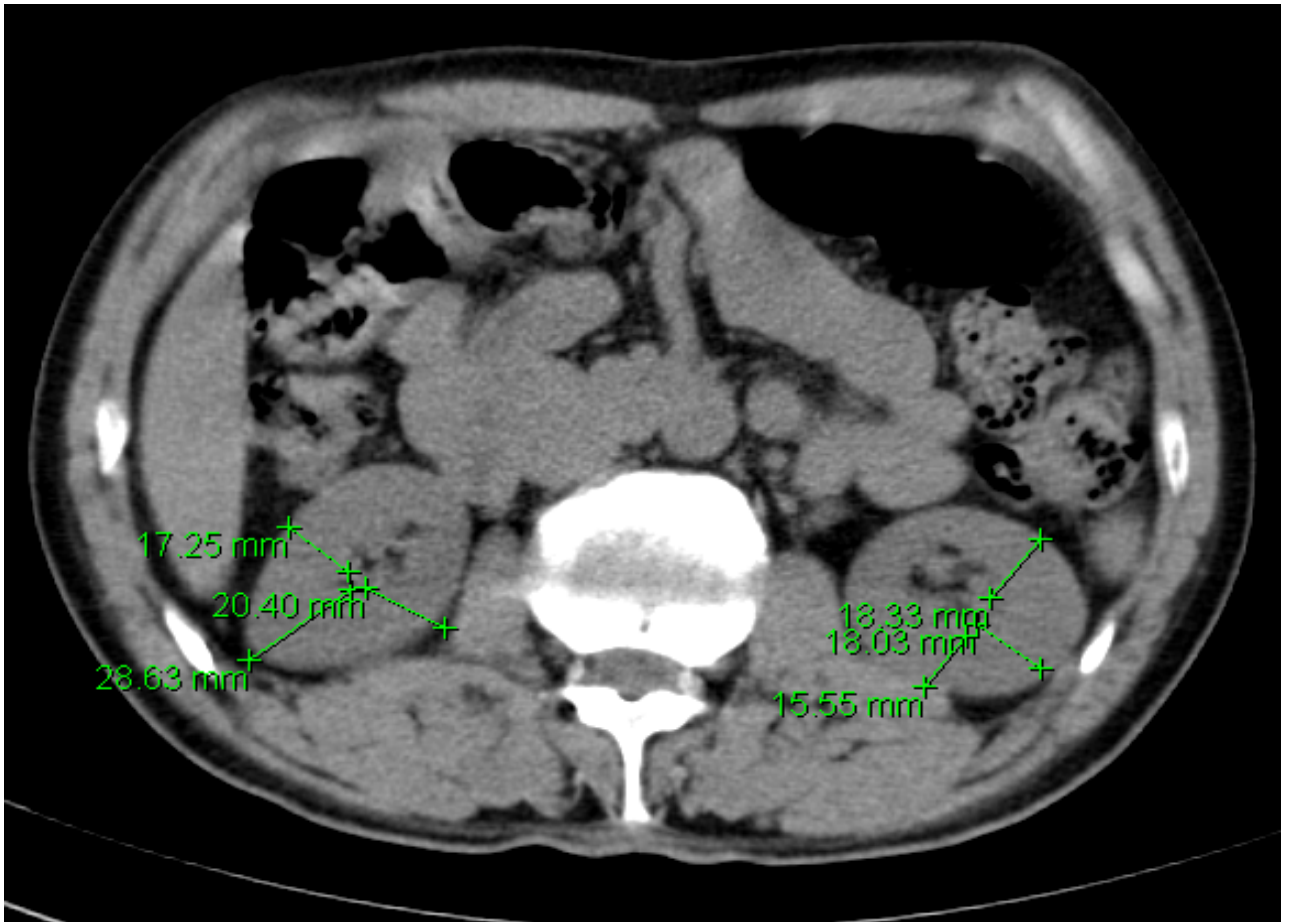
Method 4 – Axial pre contrast CT sections of the abdomen at the level of lower pole of both the kidney where the collecting systems have just appeared, shows measurement of three values (anterior-inferior, posterior-inferior and inferior-lateral) of both the kidneys as in Relative Mean Parenchymal Area Method.
